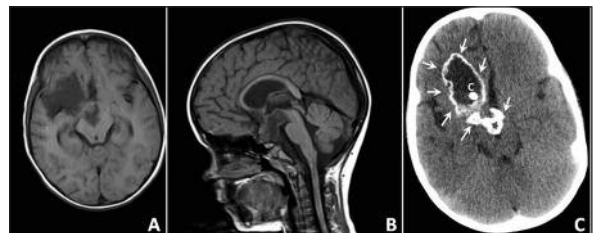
Axial (A), sagittal (B) T1W MR images demonstrates the significantly shrinkage of the cystic tumor and CSF-like fluid intensity after the one cycle of treatment. Axial NECT scan (C) exhibits the apparent cyst wall calcification and also increase the calcified portion of the lesion (arrows) following three cycles of treatment. C: catheter.
